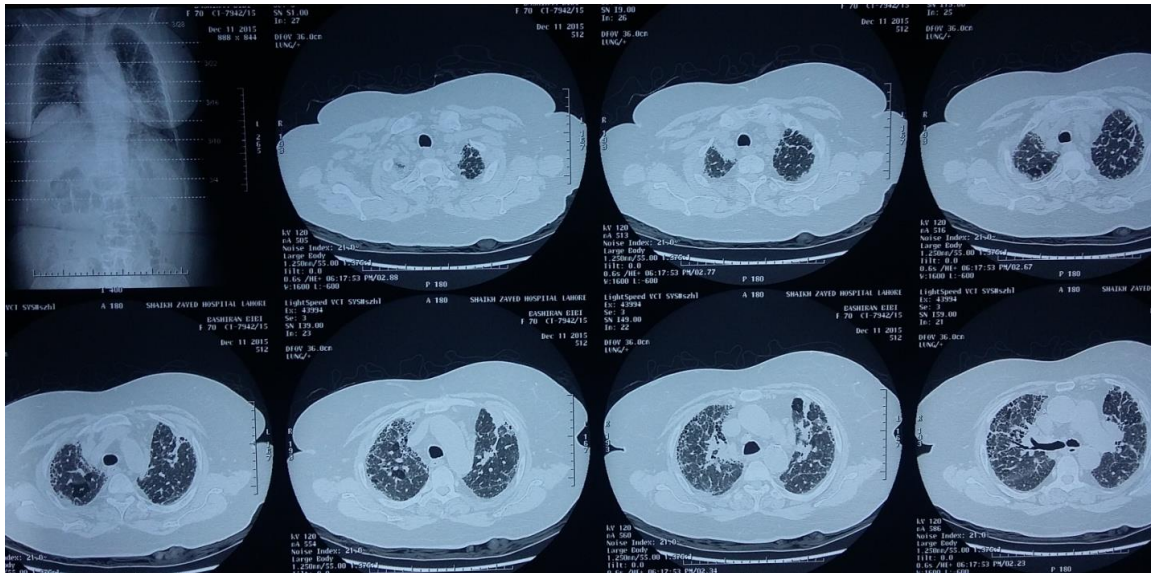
HRCT chest mages from the level of trachea to carina showing bilateral diffuse areas of GGOs, interspersed with fibrotic foci characterized by interlobar and intralobular septal thickening and honey combing. There is bilateral loss of volume predominantly on left side.
